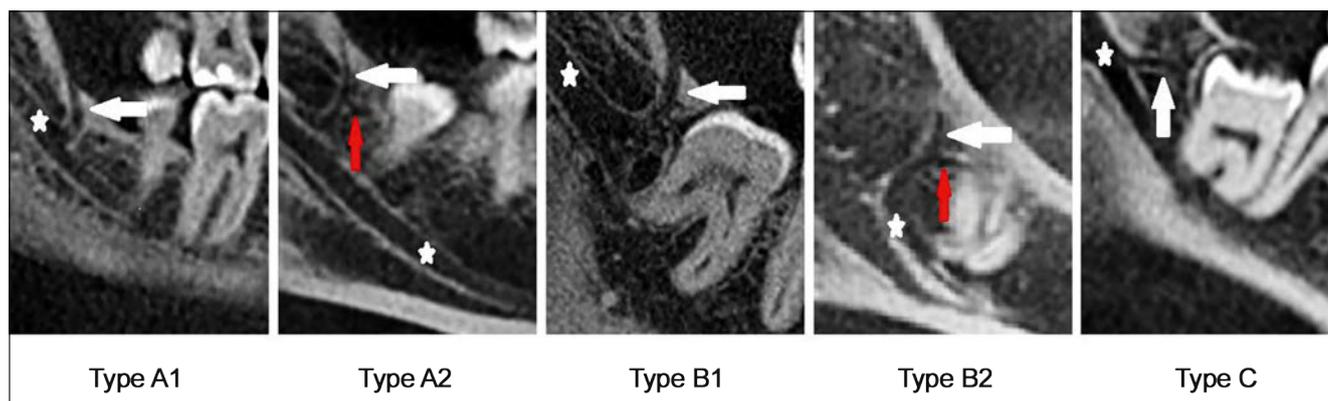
Examples of the various types of the retromolar canal (RMC) in the CBCT recording (sagittal sectional plane): Type A1 (vertical course); type A2 (vertical course with horizontal branch); type B1 (curved course); type B2 (curved course with horizontal branch); type C (horizontal course); white arrow = RMC; red arrow = horizontal branch; asterisk = mandibular canal
